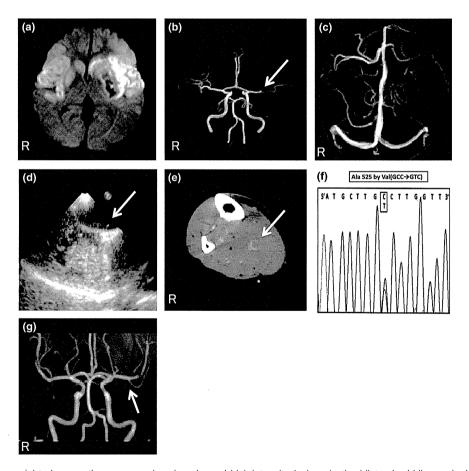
(a) Diffusion-weighted magnetic resonance imaging showed high-intensity lesions in the bilateral middle cerebral artery territories. (b) Magnetic resonance angiography showed stenosis of the left middle cerebral artery (arrow). (c) Magnetic resonance venography showed no abnormality. (d) Transesophageal echocardiography showed a patent foramen ovale (arrow). (e) Contrast-enhanced computed tomography showed thrombus in the right soleus vein (arrow). (f) Direct DNA sequencing identified the mutation GCC→GTC in the *PROS1* gene, resulting in the amino acid substitution of Ala-525 by Val. (g) Follow-up magnetic resonance angiography showed recanalization of the left middle cerebral artery.
